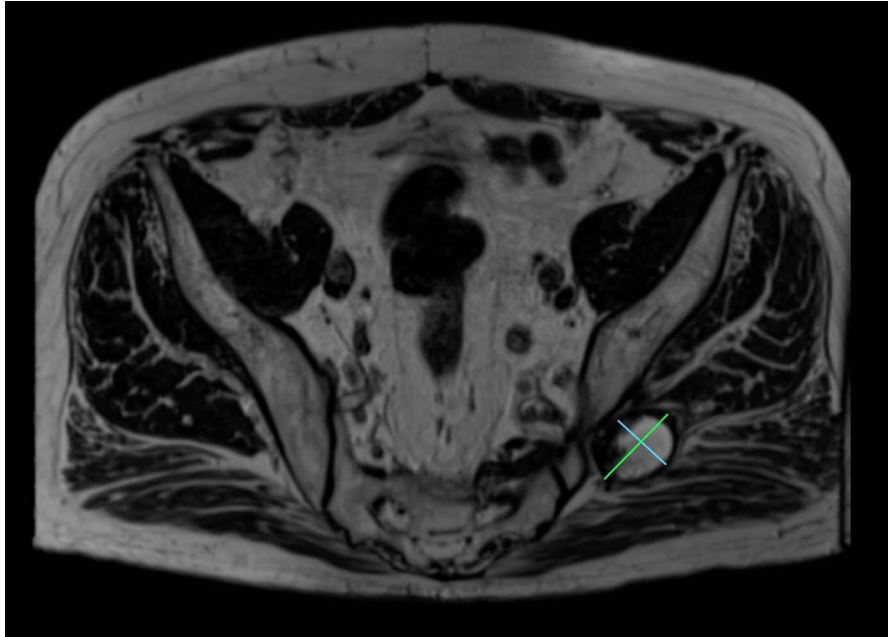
69-year-old male with mycotic pseudoaneurysm of the left SGA. MRI (November 2019) after completed exclusion of pseudoaneurysm of the left superior gluteal artery 34 x 25mm.
